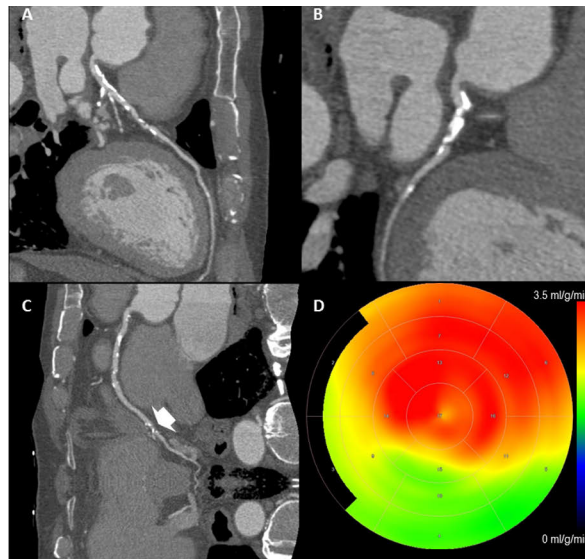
An example of a patient with elevated fPAPP-A concentration (1.4 mIU/L), extensive coronary atherosclerosis (coronary artery calcium score 2 982) and an obstructive lesion (arrow in panel C) in the right coronary artery. Figure shows coronary computed tomography angiography images of the left anterior descending (A), left circumflex (B) and the right coronary artery (C). Polar map (D) shows reduced stress myocardial blood flow by radiowater positron emission tomography in the right coronary artery territory (green color).
